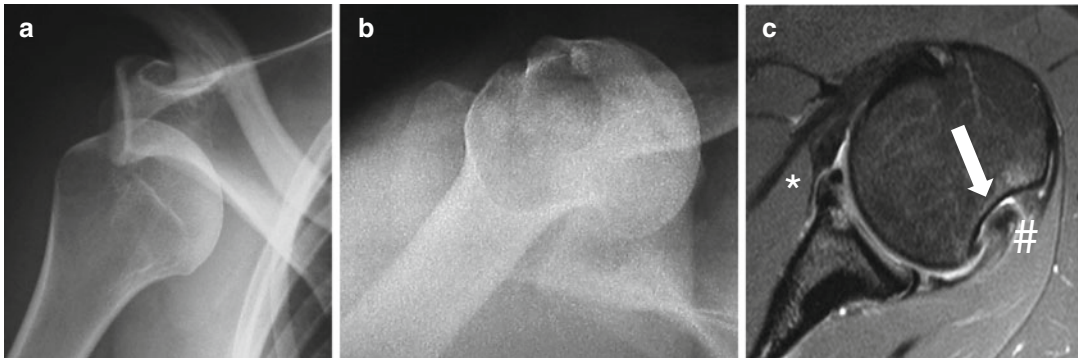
Anterior dislocation (a, b). Anteroposterior (a) and axillary view (b). MRI (c) depicting a Hill-Sachs lesion (arrow) and a GLAD lesion (*) (For definition see text). A partial avulsion of the infraspinatus is also present (#)
